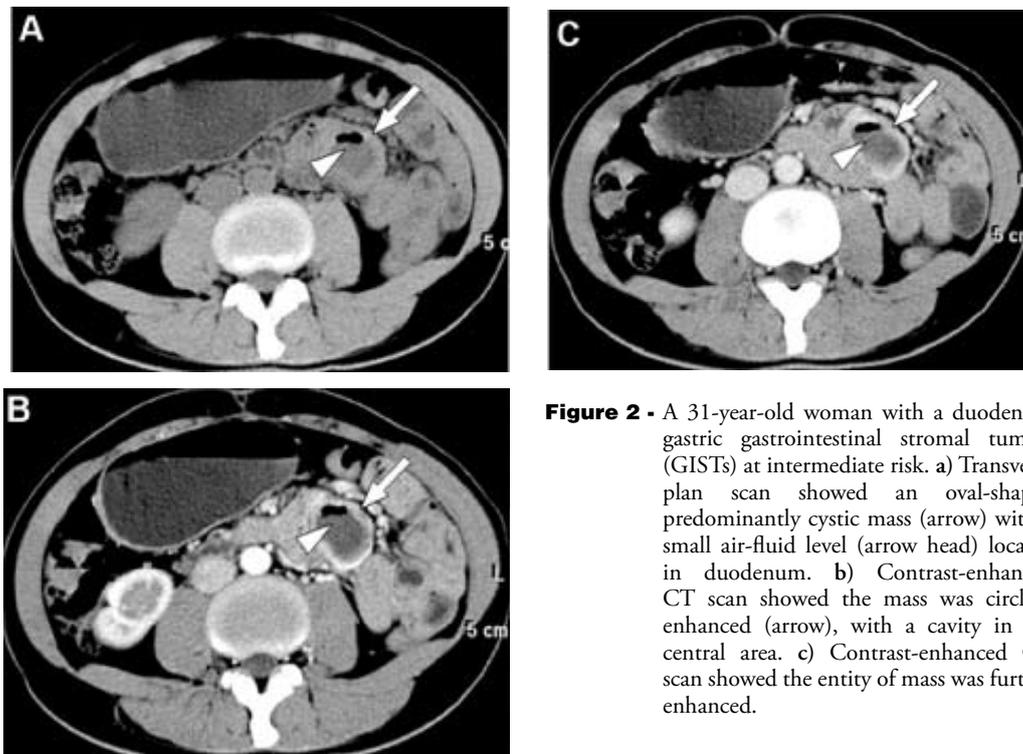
A 31-year-old woman with a duodenum gastric gastrointestinal stromal tumors (GISTs) at intermediate risk. a) Transverse plan scan showed an oval-shaped predominantly cystic mass (arrow) with a small air-fluid level (arrow head) located in duodenum. b) Contrast-enhanced CT scan showed the mass was circling enhanced (arrow), with a cavity in the central area. c) Contrast-enhanced CT scan showed the entity of mass was further enhanced.
